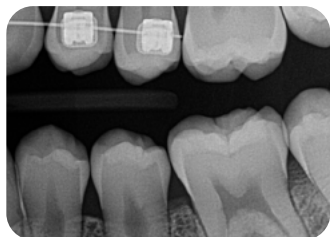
16. 2019: Left side bitewing (photo left). Right side bitewing (photo right) No evidence of decay, but hygiene discussed as related to demineralization and gingival coverage over the patient's molars.
